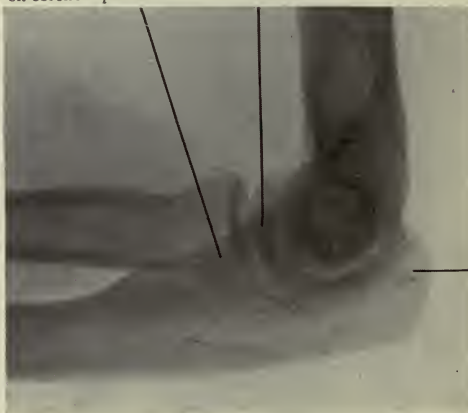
Lateral Radiograph of half-bent Elbow.
